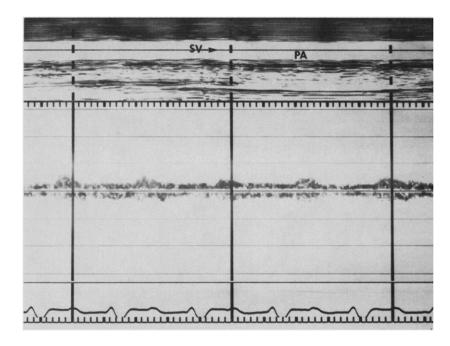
Pulsed Doppler recording from the pulmonary artery in a 13 year old patient approximately 3 weeks after a Fontan procedure. Note the markedly reduced flow pattern with systolic flow. Echocardiographic and angiographic evidence of severe decrease in left ventricular function and moderate AV valve insuficiency was also found. Abbreviations as before.
